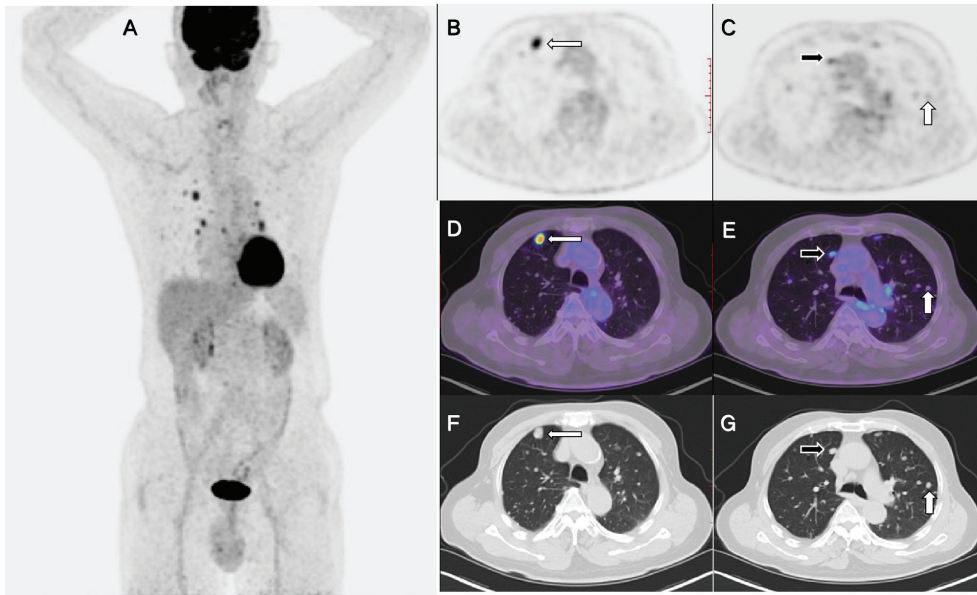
PET/CT findings of pulmonary metastasis from EMC. (A) Maximal intensity projection reveals a numerous number of lesions with FDG uptake in the chest. (B) EMC lung metastases exhibit high FDG uptake on PET. (C) EMC lung metastases exhibit low or negligible FDG uptake on PET. (D) PET/CT fusion images showed high FDG uptake. (E) PET/CT fusion images showed low or negligible FDG uptake. (F) Appearance of nodules with high FDG uptake on CT image. (G) Appearance of nodules with low or negligible FDG uptake on CT image. FDG, fluorodeoxyglucose; CT, computed tomography; PET, positron emission tomography; EMC, epithelial-myoeplithelial carcinoma.
